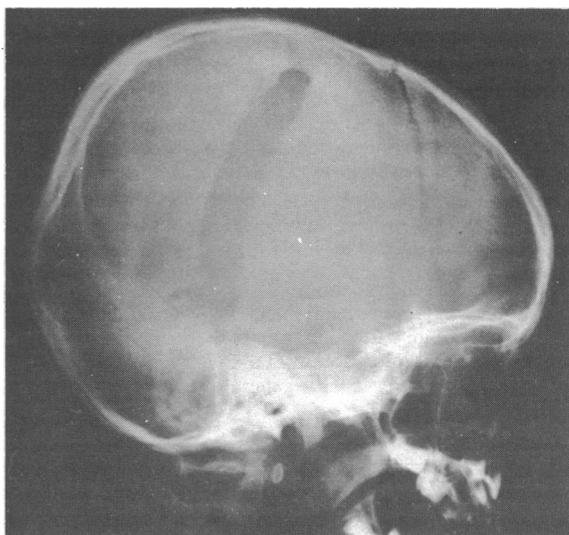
X-ray appearance at time of second admission.
